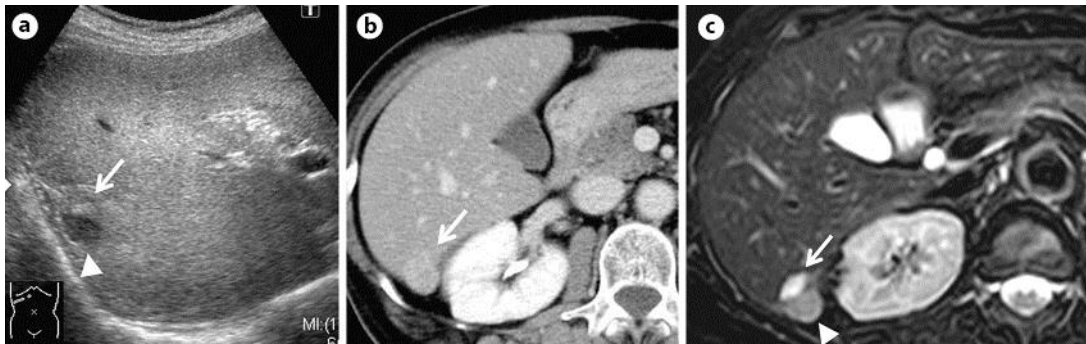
Grayscale US showed a tumor with a snowman-like appearance and a relatively clear boundary in the S6 of the liver, with hypo- and hyperechoic areas in the lateral (arrowhead) and medial parts (arrow) of the lesion, respectively (a). Contrast-enhanced CT showed a tumor prolonged enhancement in the equilibrium phases (arrow) (b). MRI showed high intensity in the lateral part of the tumor (arrowhead) and higher intensity in the medial part of the tumor (arrow) on heavy T2-weighted imaging (c).
